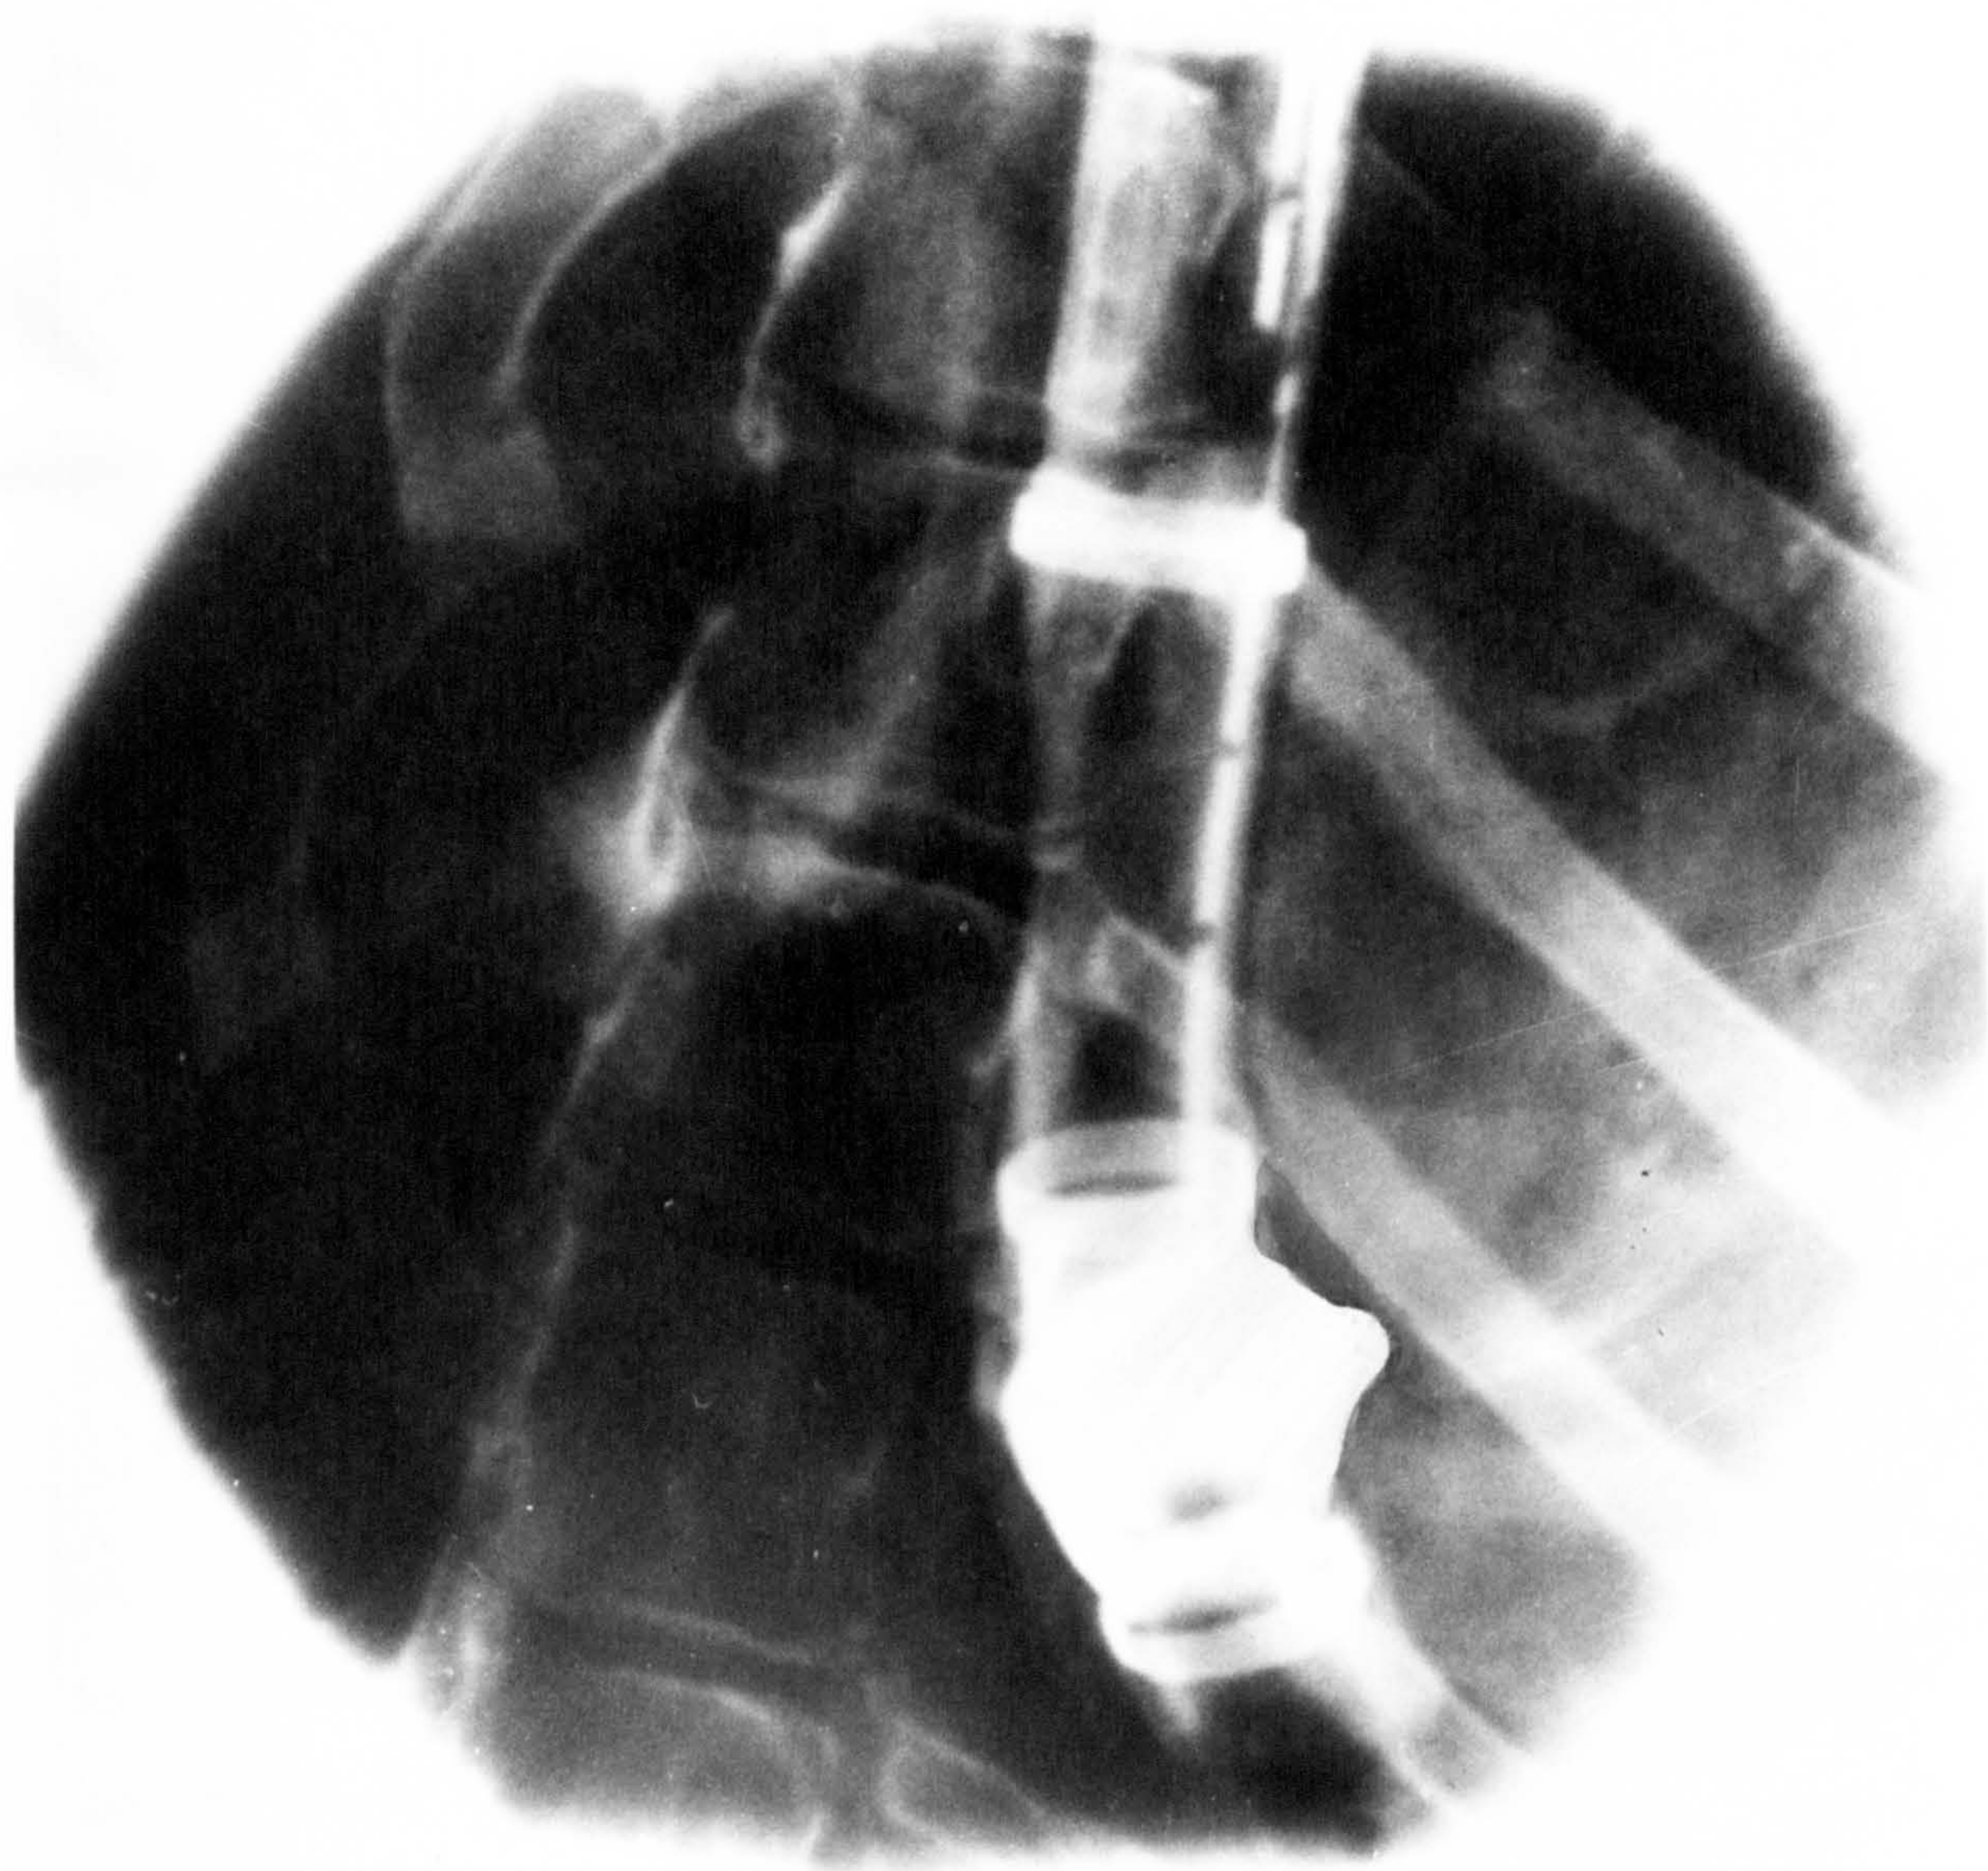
1.    RADIOGRAPH: CARLENS TUBE IN SITU.
